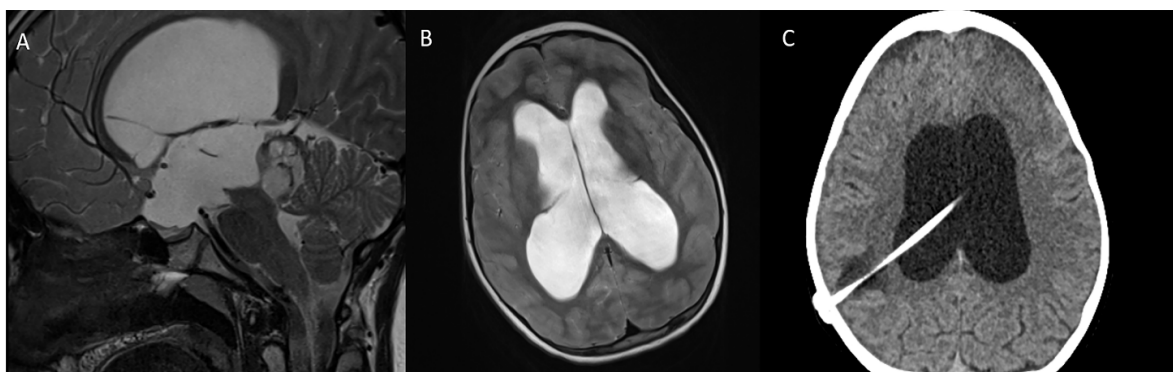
MRI images of a patient with pilocytic astrocytoma pathology with ETB+ETV performed due to a tectal tumor
